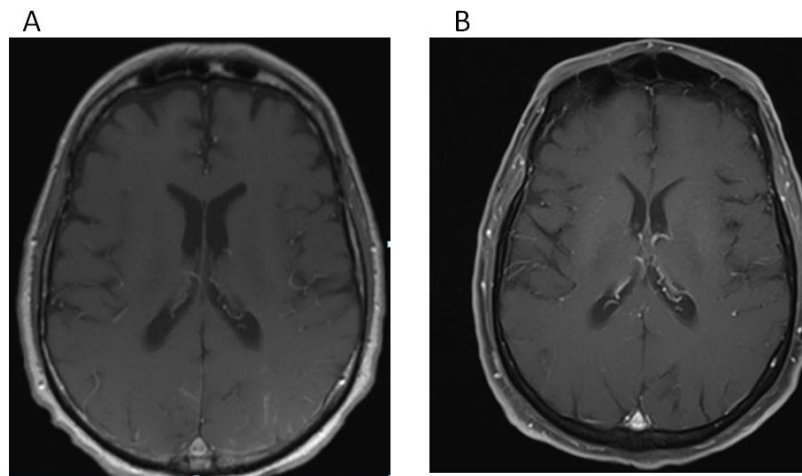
MRI Brain with contrast
